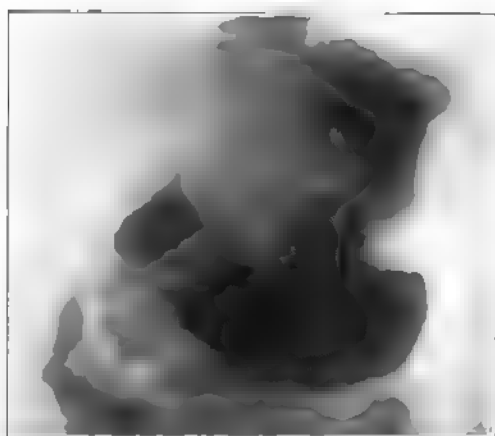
(A74,843, X-ray 17,585.) O. H. L., male, aged fifty-seven. Radiogram shows marked filling defect of the pars cardiaca and media. Possible carcinoma of stomach. Operation: Carcinoma cardiac end of stomach. Extensive glandular involvement. Also metastasis in pelvis.
